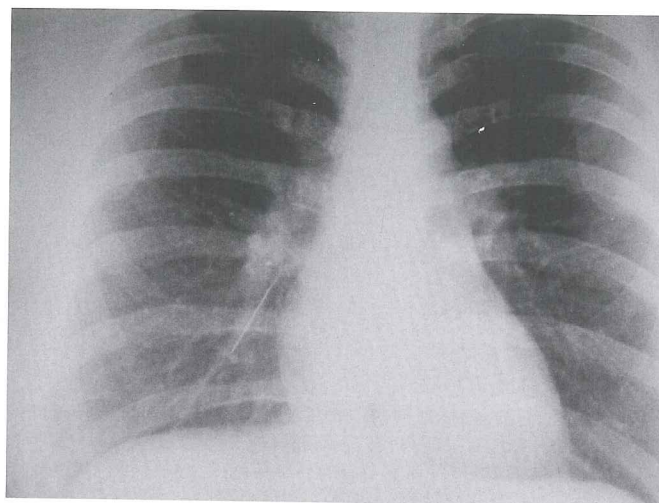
PA chest radiography of patient 3
